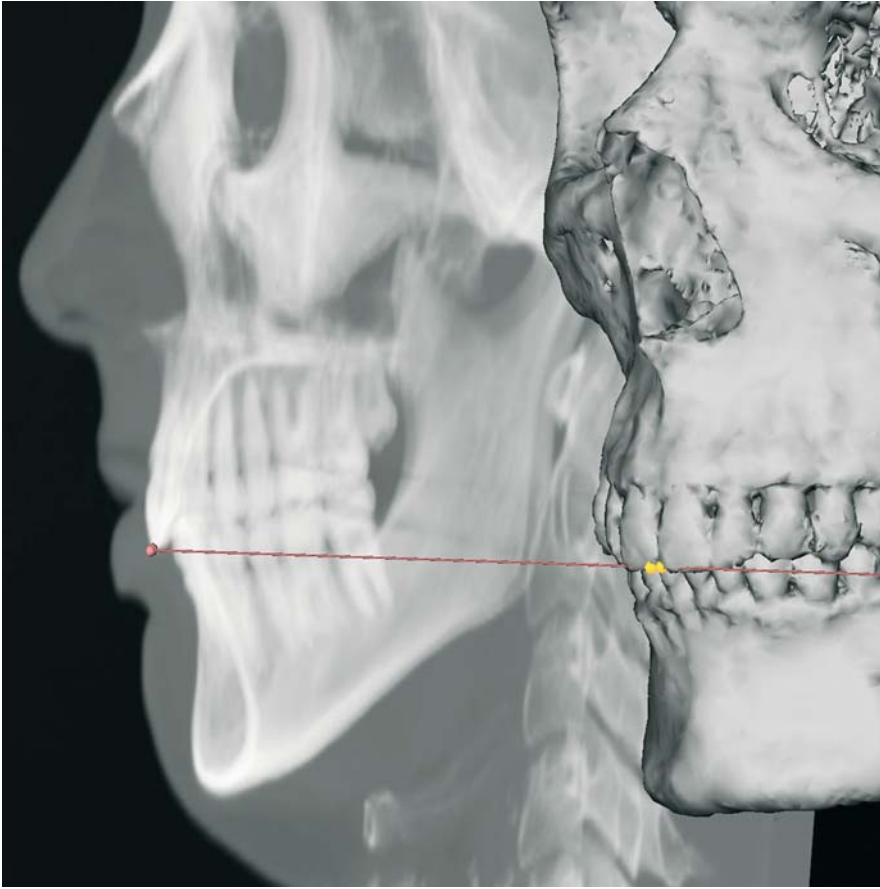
Upper Incisor (UI_r – UI_l) landmarks. Virtual lateral cephalogram linked to the 3-D hard tissue surface representation (3-D CT, patient K.C.)
